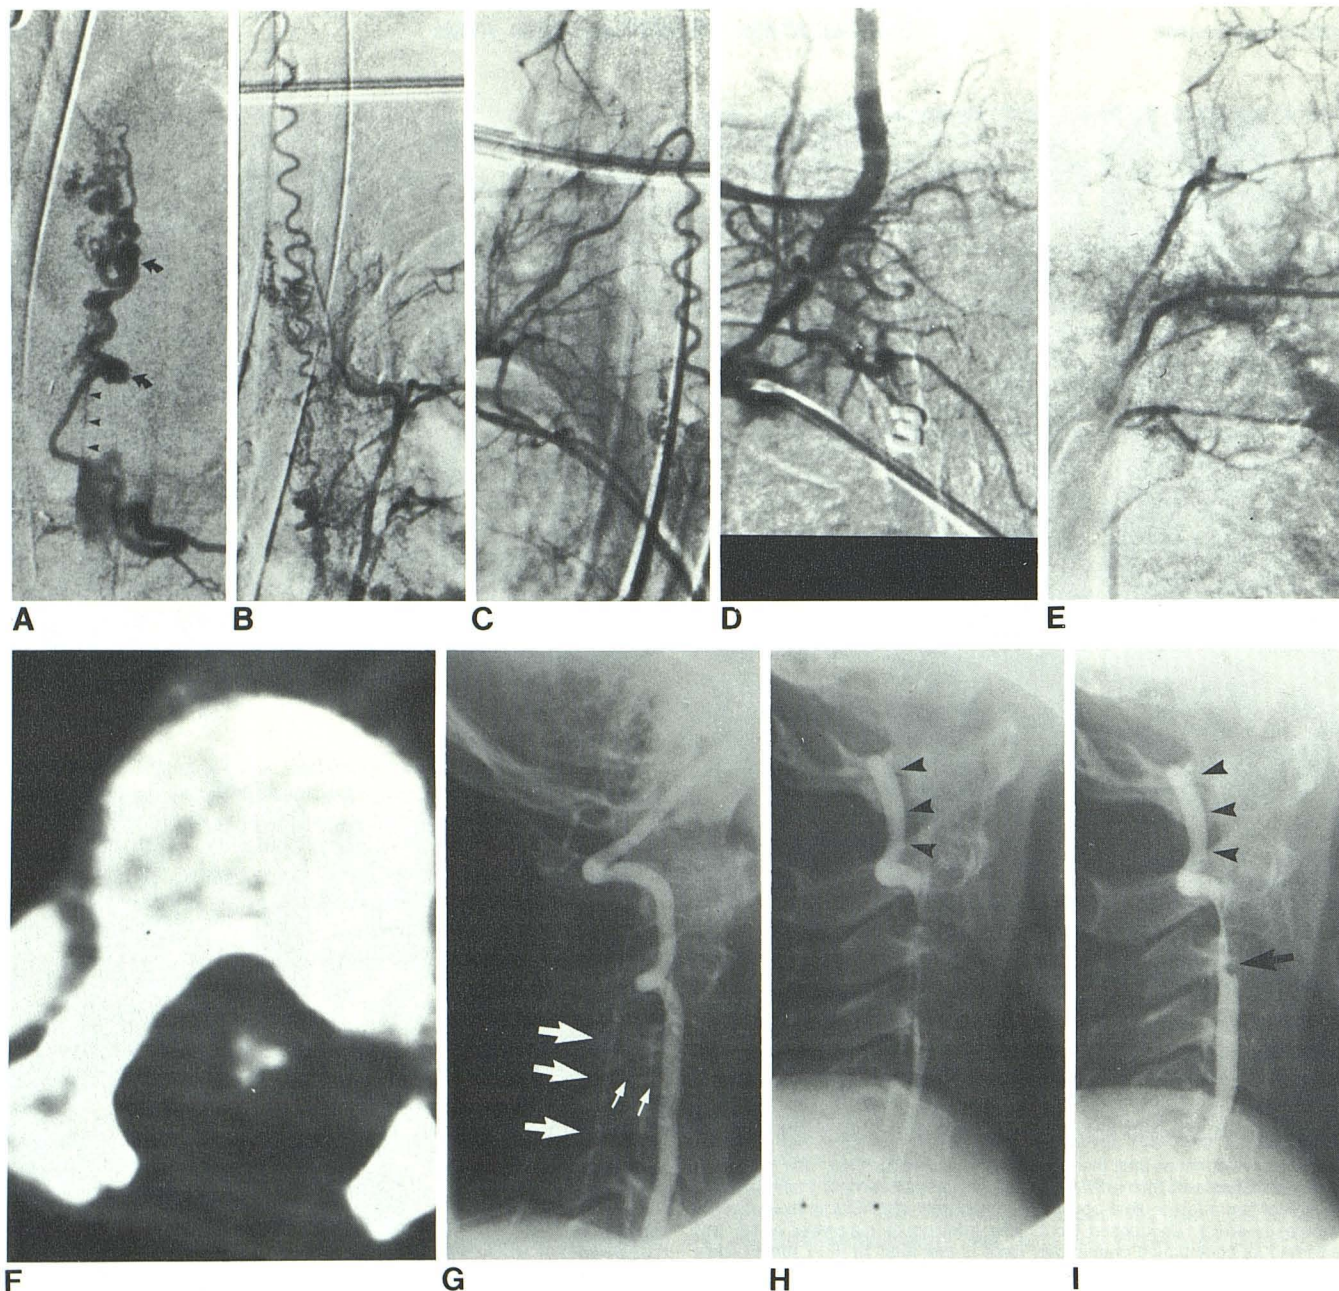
Case 2. A, Left T8 intercostal arteriogram about 1 year after surgery. Anterior spinal artery (*arrowheads*) arises from anterior part of AVM. Two aneurysmal segments (*arrows*) are present. B, Left supreme intercostal arterial injection shows communications with serpiginous radiculomedullary vessel, which arises from C, right thyro/costocervical artery. D, Right subclavian injection. Superior supplying vessel is no longer filled. E, Injection into left T8 intercostal artery (with reflux to higher ones). Supply to AVM is closed. F, Follow-up CT scan of spine through AVM 2 months after embolization. Barium-impregnated particles within cord confirm intramedullary location. G, Right vertebral arteriogram shows last identified artery supplying malformation (*small*
